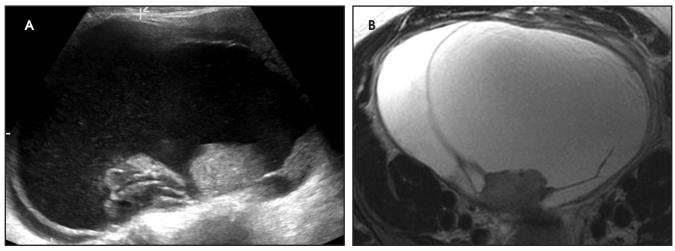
Ovarian mucinous adenocarcinoma. (A) Ultrasound examination demonstrates a >10 cm multilocular cyst with solid components with color flow (not shown). (B) Corresponding T2 MRI shows similar findings of a multilocular cyst with a solid component that enhanced avidly (not shown) (O-RADS MRI 5).
